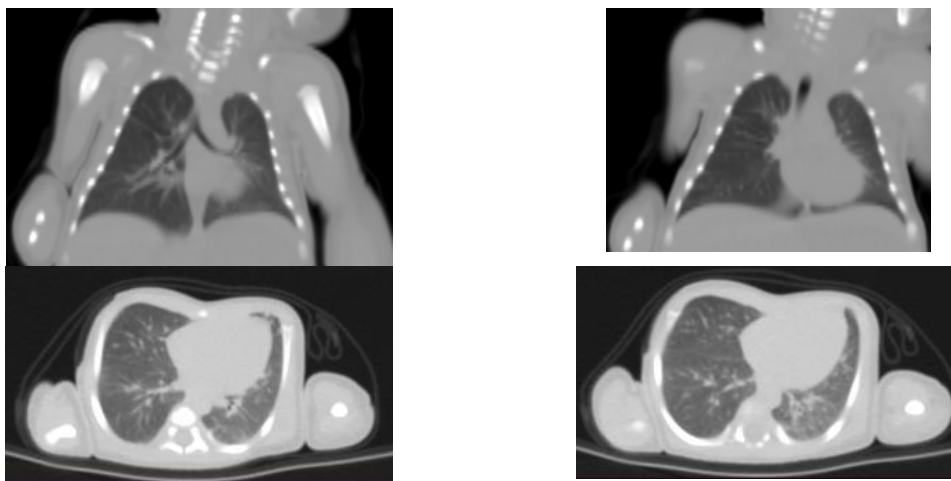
Thorax contrast CT scan post removal of the chest intercostal drainage
